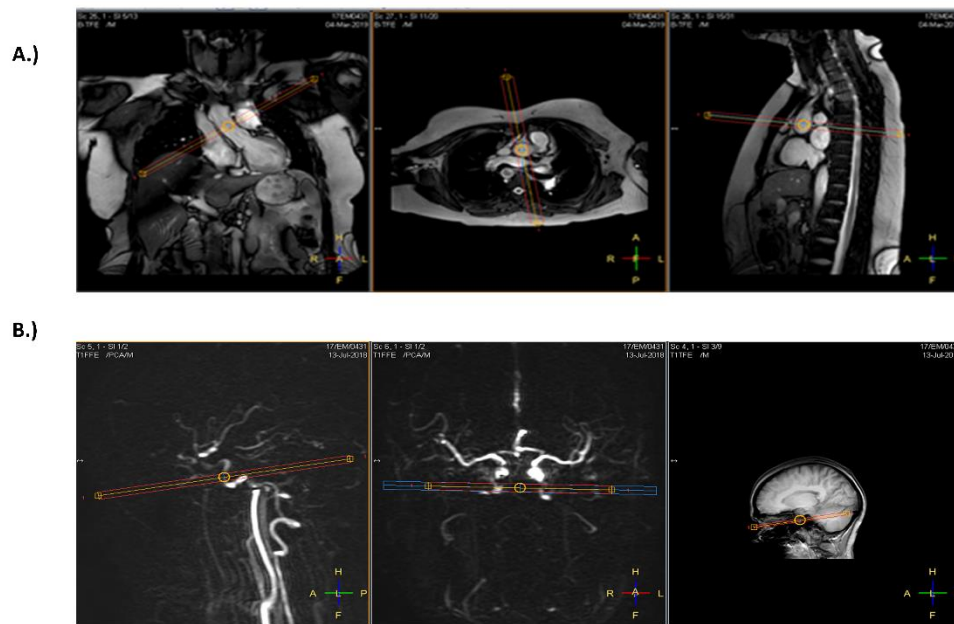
Planning scans for phase contrast MRI sequences A) Ascending Aorta (AO) flow B) Internal carotid flow.
